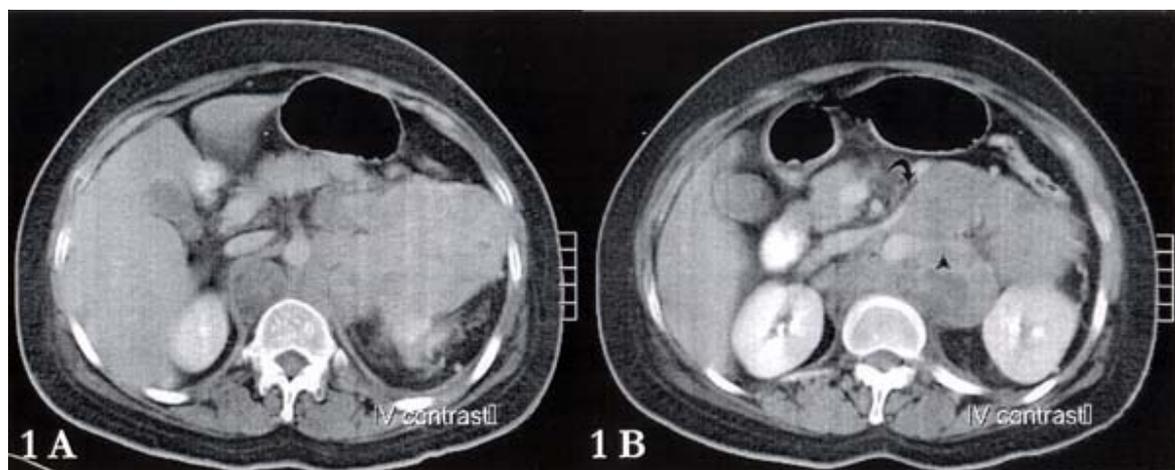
(A) CT scan of the abdomen at the level of superior mesenteric artery origin showed a large left suprarenal mass with enlarged retrocaval and para-aortic lymph nodes. (B) At the level of left renal artery origin (arrowhead), the mass extended into left renal hilum encasing the left renal artery and stretching of the left renal vein (curved arrow) were noted
